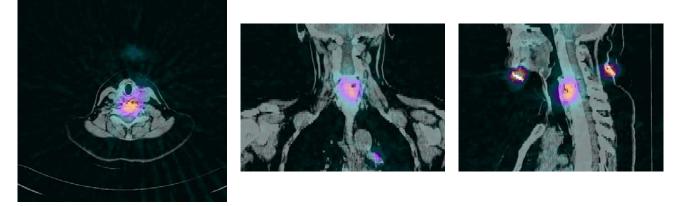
SPECT-CT fusion in patient with thyroid cancer and metastases to spine.
